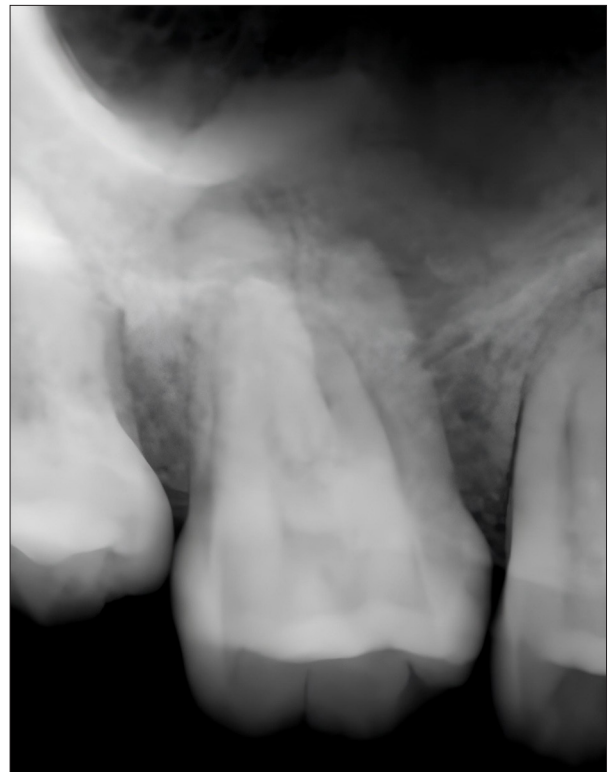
The initial periapical radiograph of the first molar of the right maxilla.
